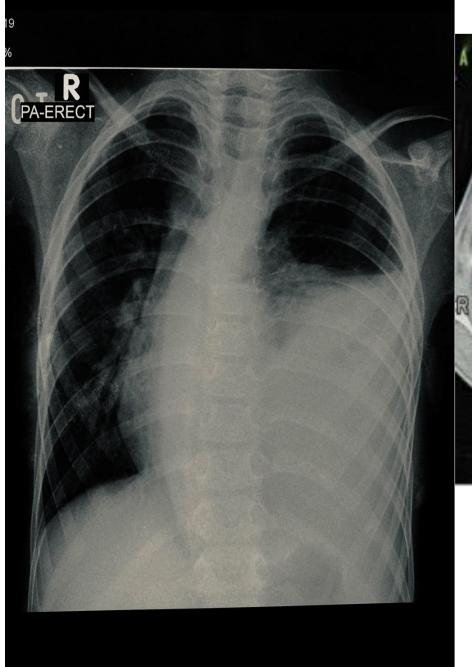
Shows erect chest radiograph during his presentation which shows left massive pleural effusion.
